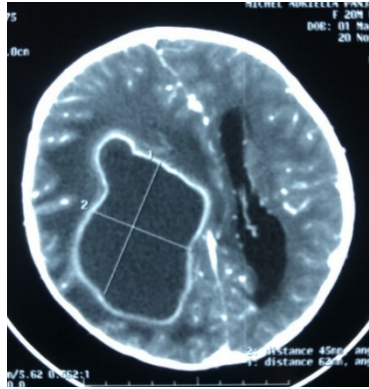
Head Contrast CT scan: axial
